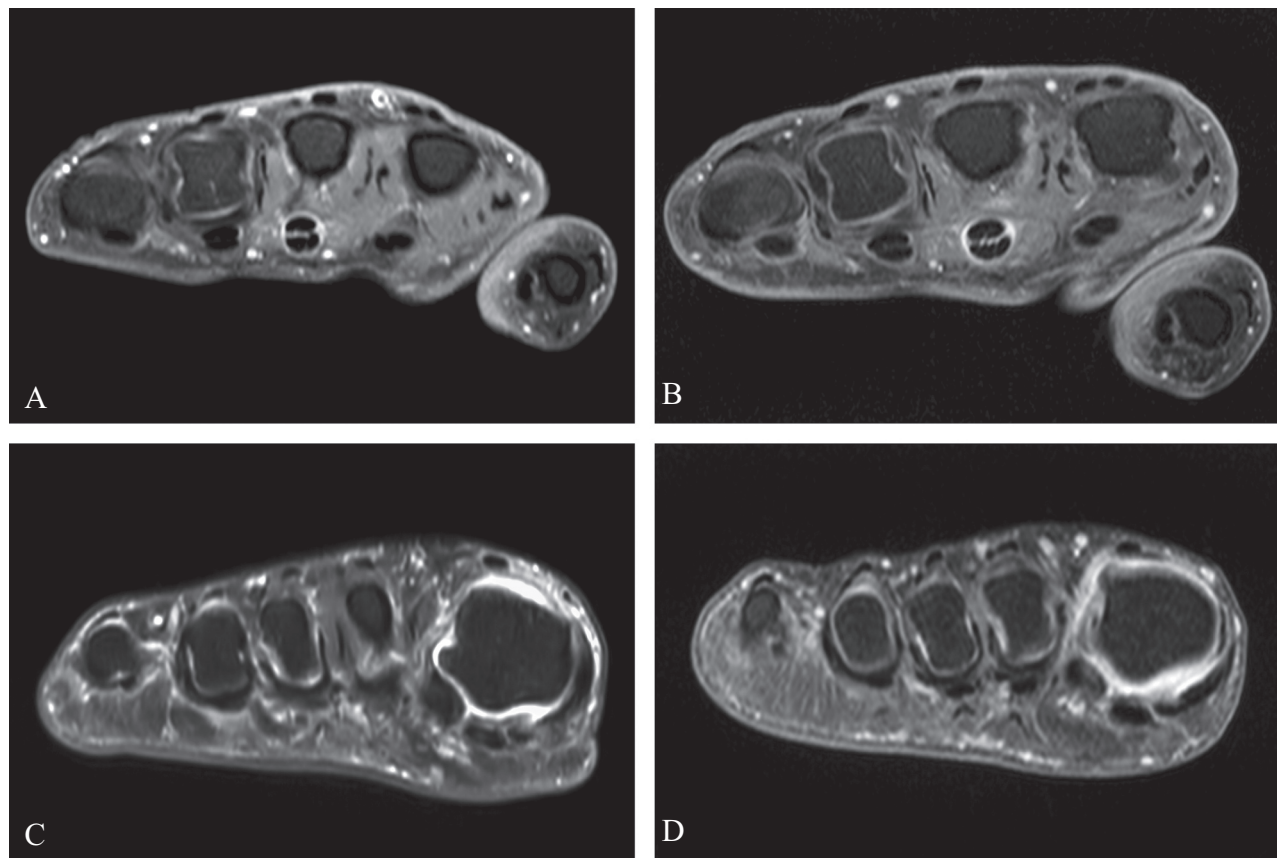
Examples of a contrast-enhanced magnetic resonance imaging (MRI) sequence of the metacarpophalangeal (MCP) region with tenosynovitis and metatarsophalangeal (MTP) region with synovitis in the same patient, scanned at 3 T and 1.5 T. (A, B) Tenosynovitis of the third flexor tendon sheath in the MCP region on 3.0 T (A) and 1.5 T (B) MRI. (C, D) Synovitis of the first MTP joint on 3.0 T (C) and 1.5 T (D) MRI.
